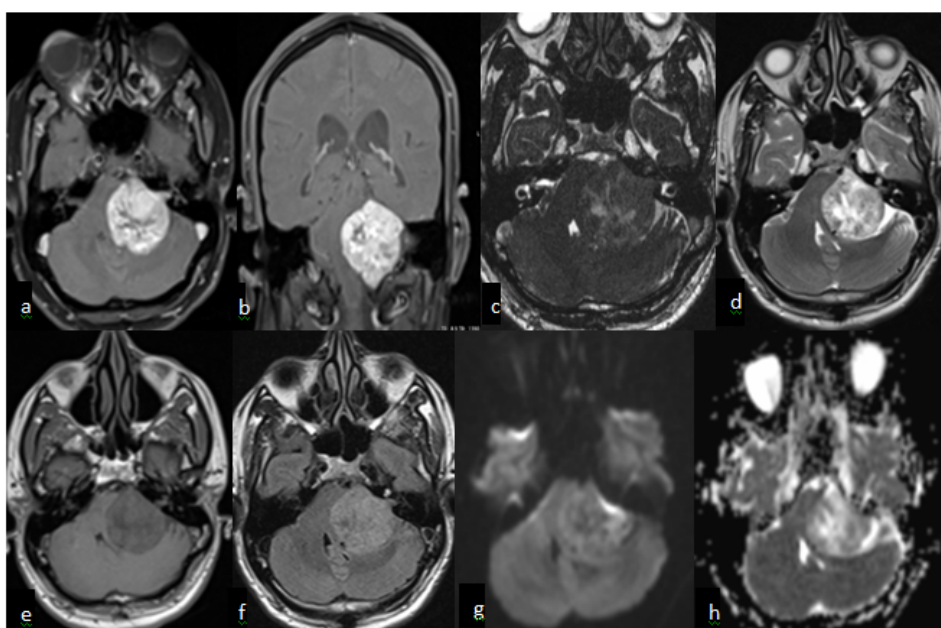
Vestibular schwannoma in patient presenting with left sided hearing loss, vertigo and headache. (a,b) Axial and coronal post-contrast T1-weighted image demonstrates a heterogeneously enhancing mass lesion shows typical “ice cream on-cone appearance” with a central non-enhancing region located in the left cerebellopontine angle. The mass widens the left porus acousticus and extends into the left internal auditory canal. There is associated mass effect upon the pons and cerebellar peduncle with significant compression of the fourth ventricle. (c) Constructive interference in steady state axial image shows left CPA mass lesion with intracanalicular extension (d) T2-weighted axial imaging showing left sided heterogeneous cerebellopontine angle lesion with internal hypointense areas. (e) It is hypointense on T1-weighted imaging and (f) relatively hyperintense on FLAIR. (g,h) The lesion show heterogeneous diffusion restriction
